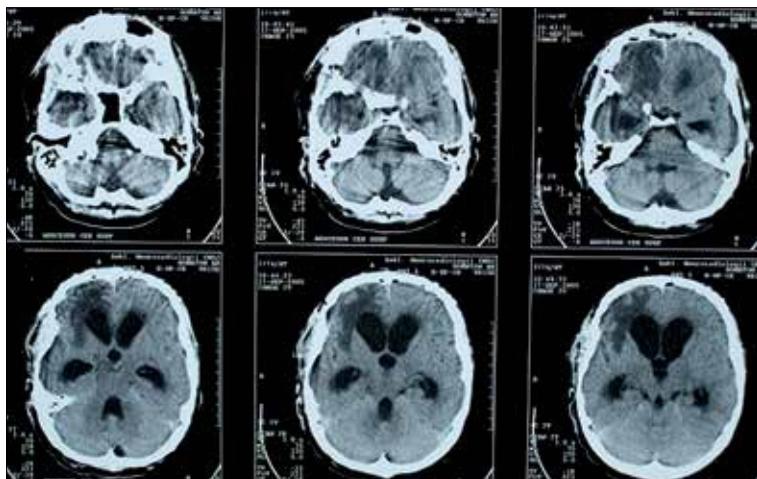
Results from a CT scan of MF’s brain, one month after the accident. Dilatation of the lateral ventricles, signs of encephalomalacia of the right frontal lobe.
